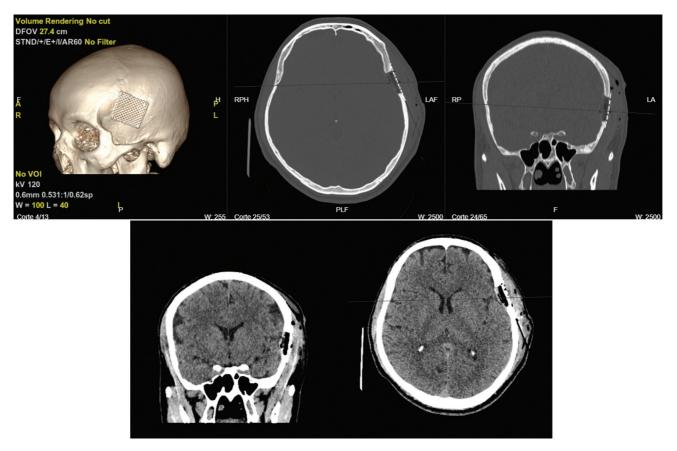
Postoperative head computed tomography scan with 3D reconstruction. Axial and coronal views of the brain and bone windows are shown. Complete resection of the solid and lytic component of the lesion was achieved, with coverage of the resulting osseous defect.
